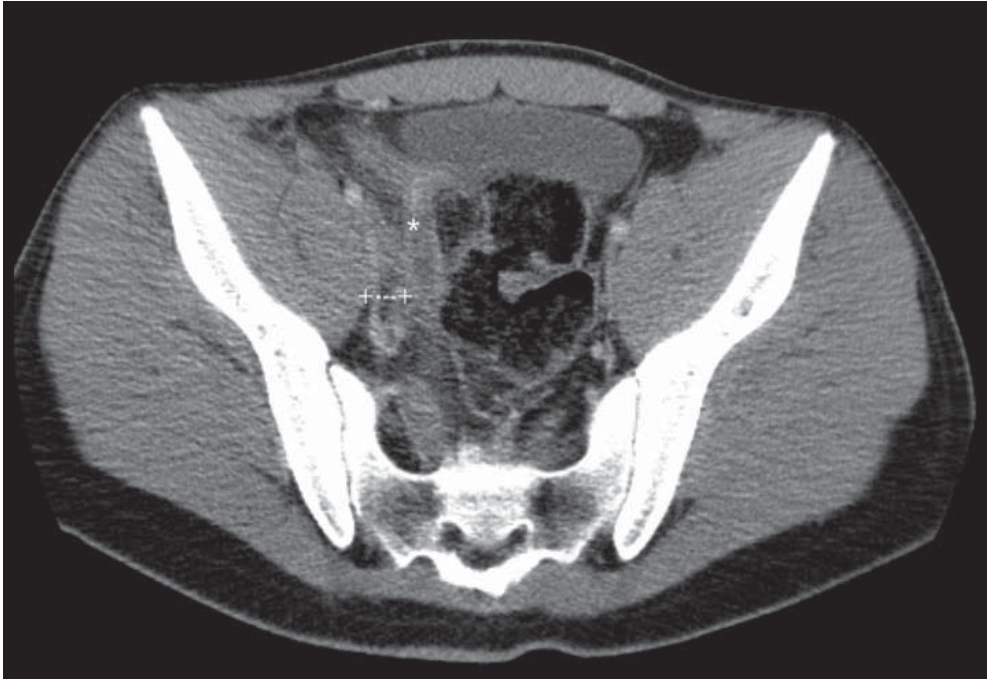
CT scan of the same patient shows classical appearance of appendicitis with periappendicular fat stranding (asterisk) and 13 mm enlarged appendix. Dotted line shows enlarged retrocecal appendix.
